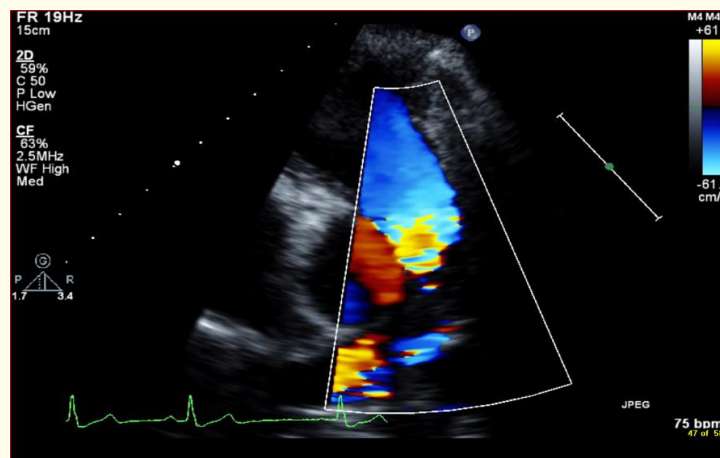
Parasternal short axis color flow shows flow acceleration and signal aliasing at area of compression supravalvular with no jet at level of pulmonary valve.
